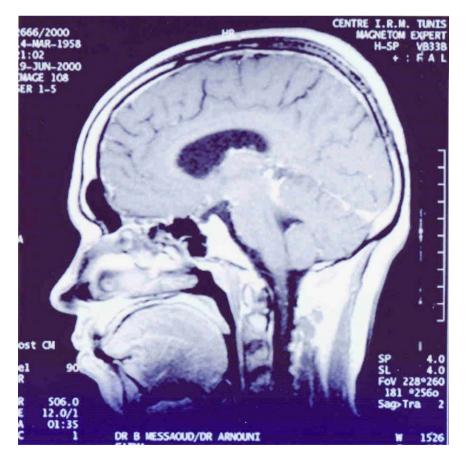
Sagittal T1-weighted image after administration of iv gadolinium showing peripheral and basilar meningeal enhancement with ventricular dilatation.
